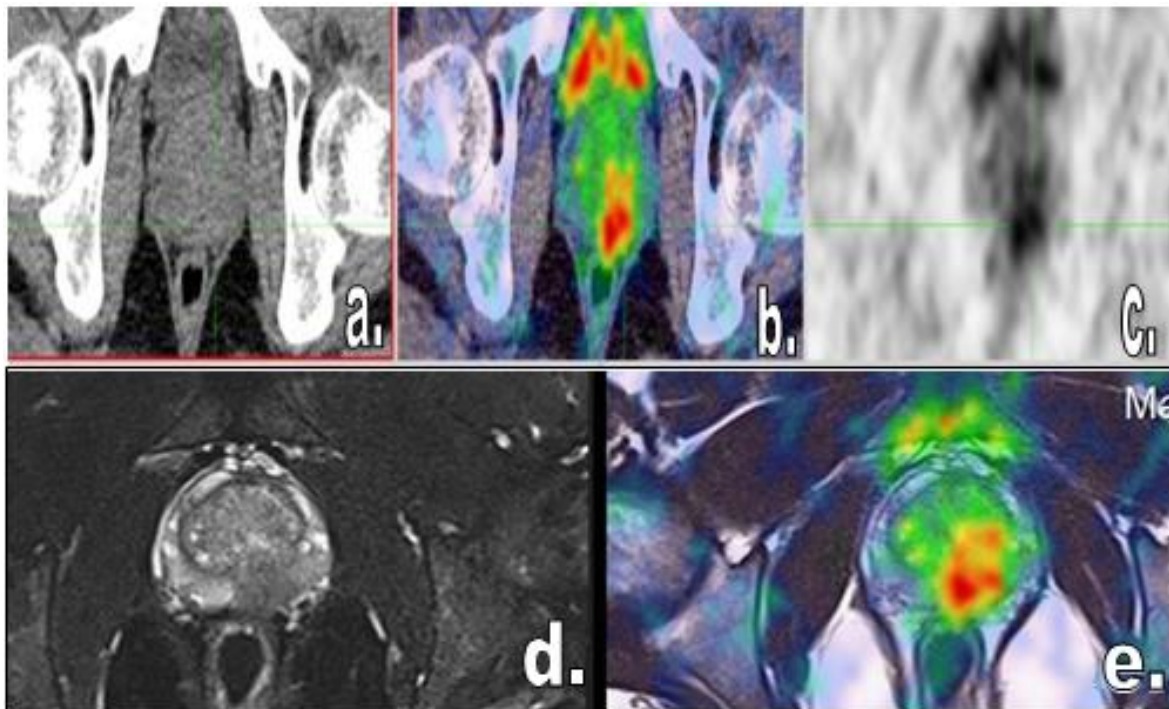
63 years old patient presented by pathologically proven prostate cancer for ⁶⁸Ga-PSMA PET/CT assessment and metastatic work up. (a) Axial conventional CT (b) axial fused PET/CT (c) axial MIP image (d) complementary axial STIR MR image (e) axial T2 MR Image with fusion show increased PSMA uptake within the left posterior peripheral zone (SUV max 5). Overlying left posterior capsular invasion and effaced recto-prostatic fat.
